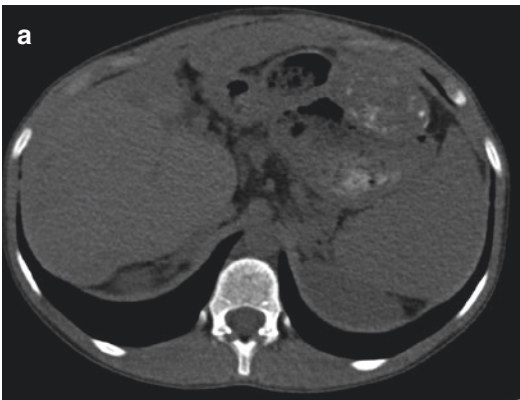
Incidental textiloma in a 12-year-old girl operated 10 years ago for a porto-enterocystostomy for biliary atresia. CT workup before liver graft transplant (a) Plain
